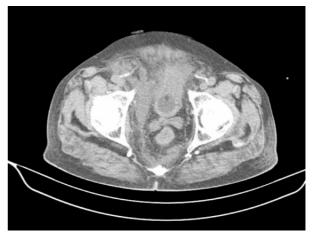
Non-contrast CT scan of the abdomen showing the collection tracking down to the right inguinal canal.
